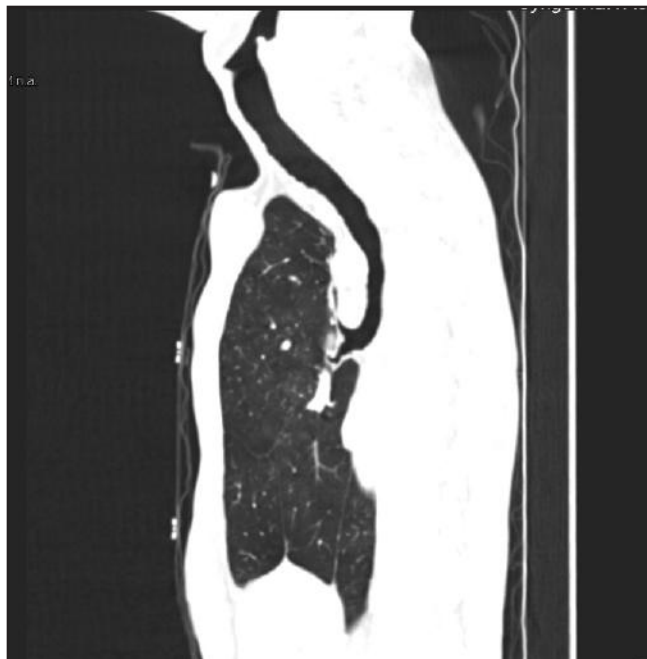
Sagittal reformatted CT thorax image viewed in lung window demonstrates the principle bronchus terminating into left mainstem bronchus with absence of right mainstem bronchus
